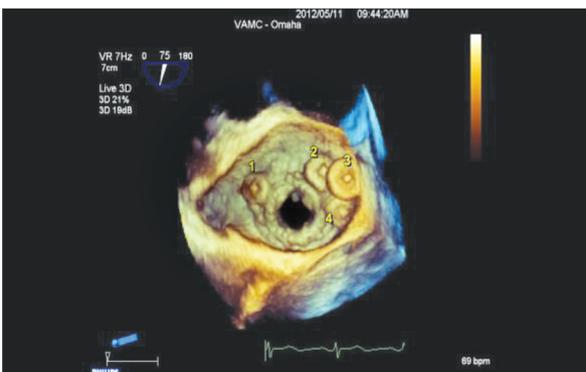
Live/three-dimensional transesophageal echocardiography en face view of the mitral valve. #1, #2, #3 and #4 represent four Amplatzer occluder devices implanted around the bioprosthetic mitral valve ring for severe paravalvular leaks.
